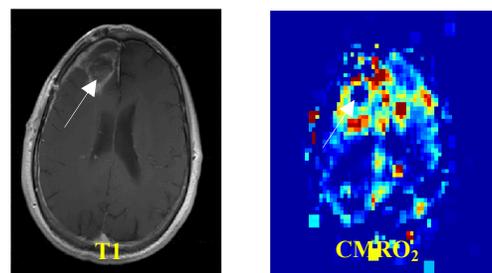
a) top: post-Gd T1-weighted image & relative CMRO₂ map b) bottom: graph for relative CMRO₂ averaging 10 patients * White arrows indicate tumor region
